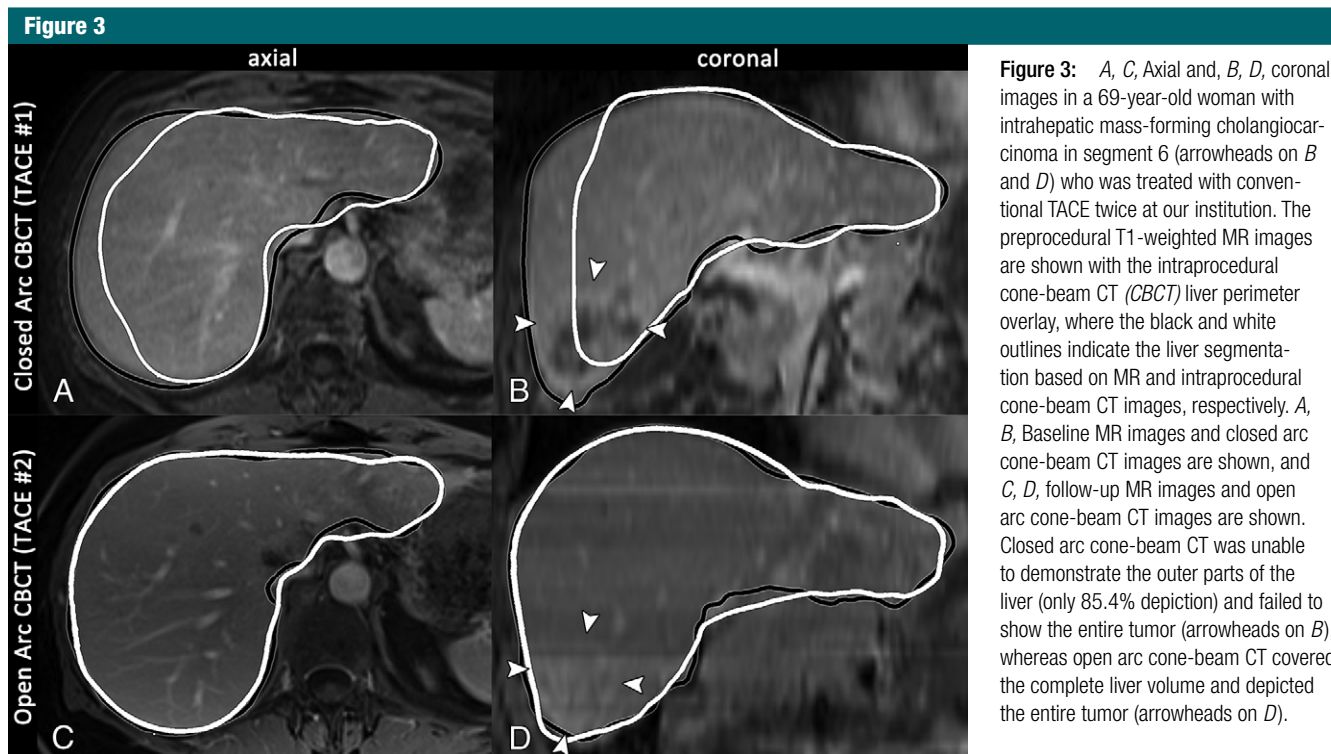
A, C, Axial and, B, D, coronal images in a 69-year-old woman with intrahepatic mass-forming cholangiocarcinoma in segment 6 (arrowheads on B and D) who was treated with conventional TACE twice at our institution. The preprocedural T1-weighted MR images are shown with the intraprocedural cone-beam CT (CBCT) liver perimeter overlay, where the black and white outlines indicate the liver segmentation based on MR and intraprocedural cone-beam CT images, respectively. A, B, Baseline MR images and closed arc cone-beam CT images are shown, and C, D, follow-up MR images and open arc cone-beam CT images are shown. Closed arc cone-beam CT was unable to demonstrate the outer parts of the liver (only 85.4% depiction) and failed to show the entire tumor (arrowheads on B), whereas open arc cone-beam CT covered the complete liver volume and depicted the entire tumor (arrowheads on D).
